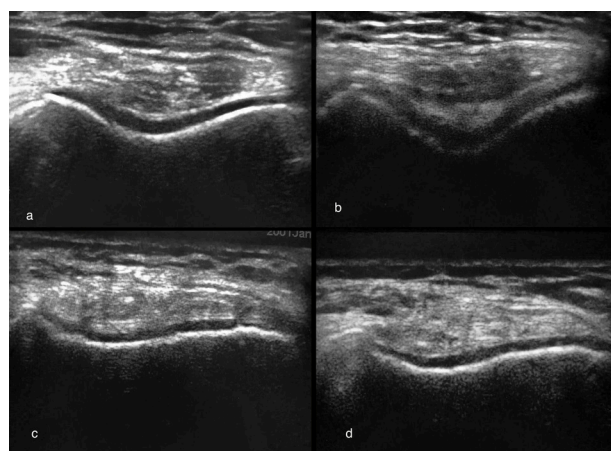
Ultrasound evaluation of femoral cartilage in four different patients, show various grades of femoral cartilage involvement in osteoarthritis.
